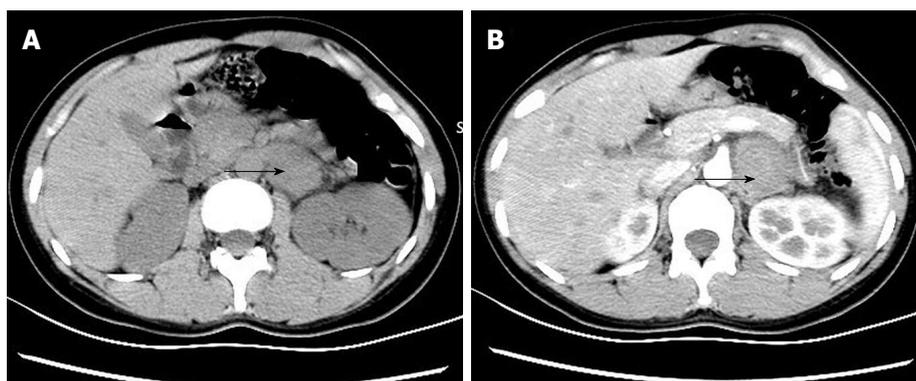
Abdomen computed tomography-scan demonstrating a 4.2 cm mass in the left adrenal. A: Computed tomography (CT) plain scan showed the mass in the left adrenal; B: CT enhancement scan showed the mass in the left adrenal with no enhanced uniform.
